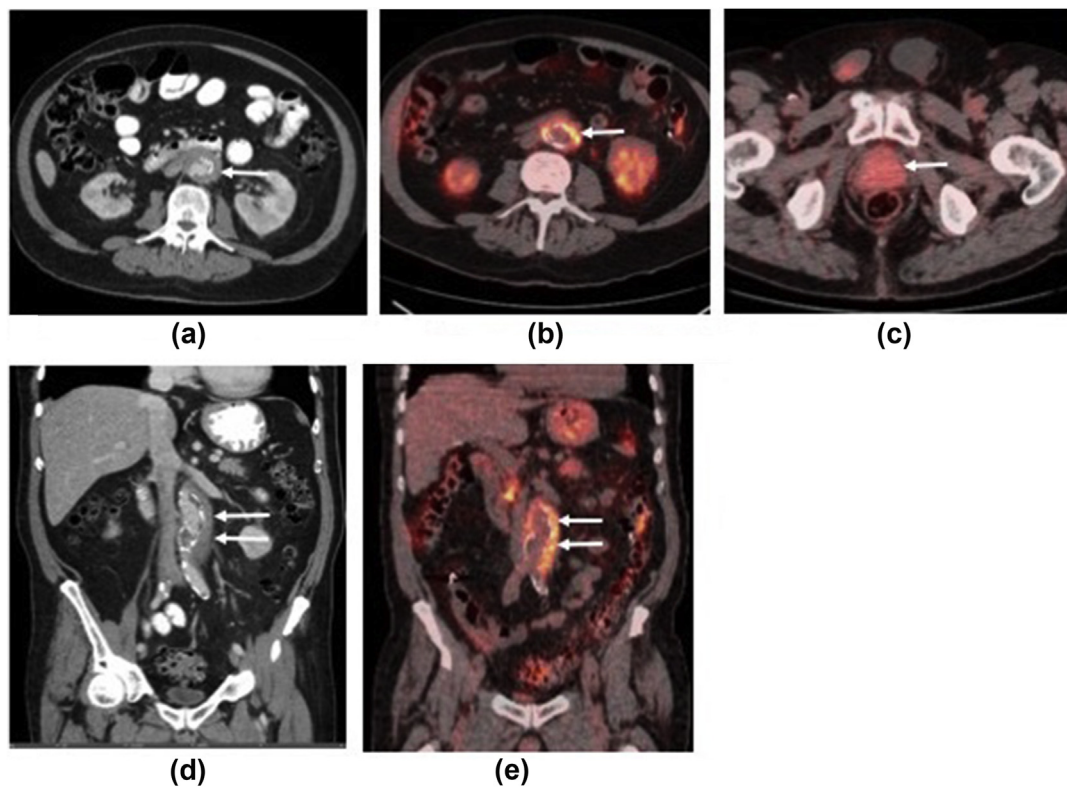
A 78-year-old man with IgG4 disease. PET-CT demonstrated peri-aortic enhancing soft tissue (a,b, arrows) with corresponding increased FDG activity (c,d, arrows) in keeping with IgG4-related aortic vascular disease. The same PET-CT also demonstrated increased FDG activity within the prostate gland, in keeping with IgG4 prostatitis (e, arrow).
